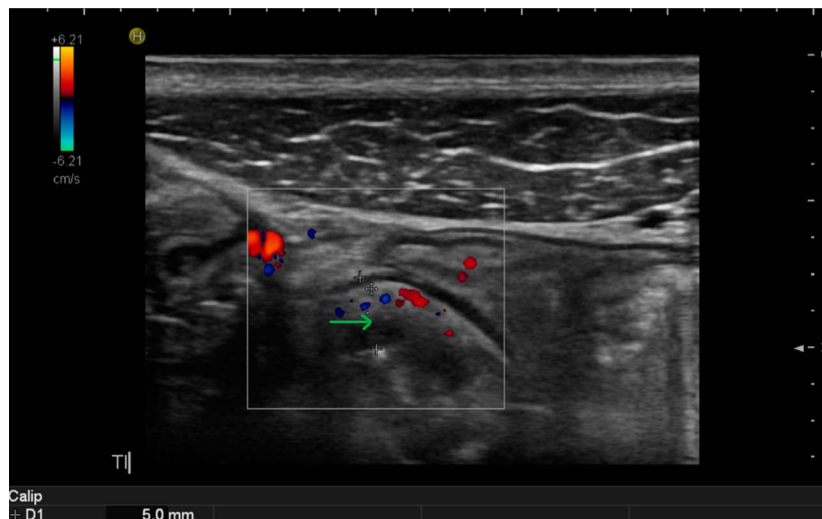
On follow-up intestinal ultrasound at 1 year, wall thickness of the terminal ileum was 5 mm (green arrow) with a modified Limberg vascularity score of 2/3.
